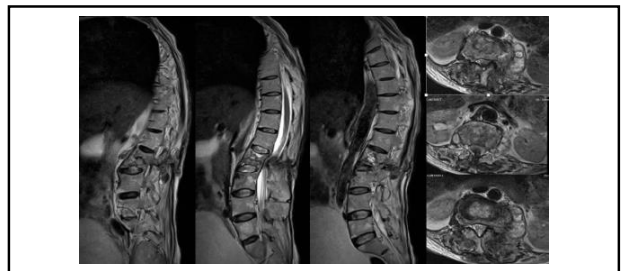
MRI of the spine
